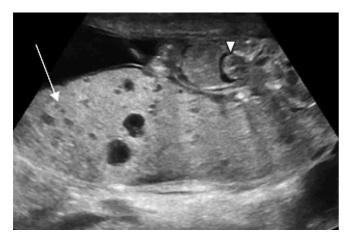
Partial molar pregnancy on transvaginal ultrasound. Note the presence of molar vesicles in the placenta (arrow) as well as fetal parts (arrow head). From Figure 35.1 of Scoutt LM, Hamper UM, Angtuaco L, eds. *Ultrasound*. Oxford, UK: Oxford University Press; 2017.
